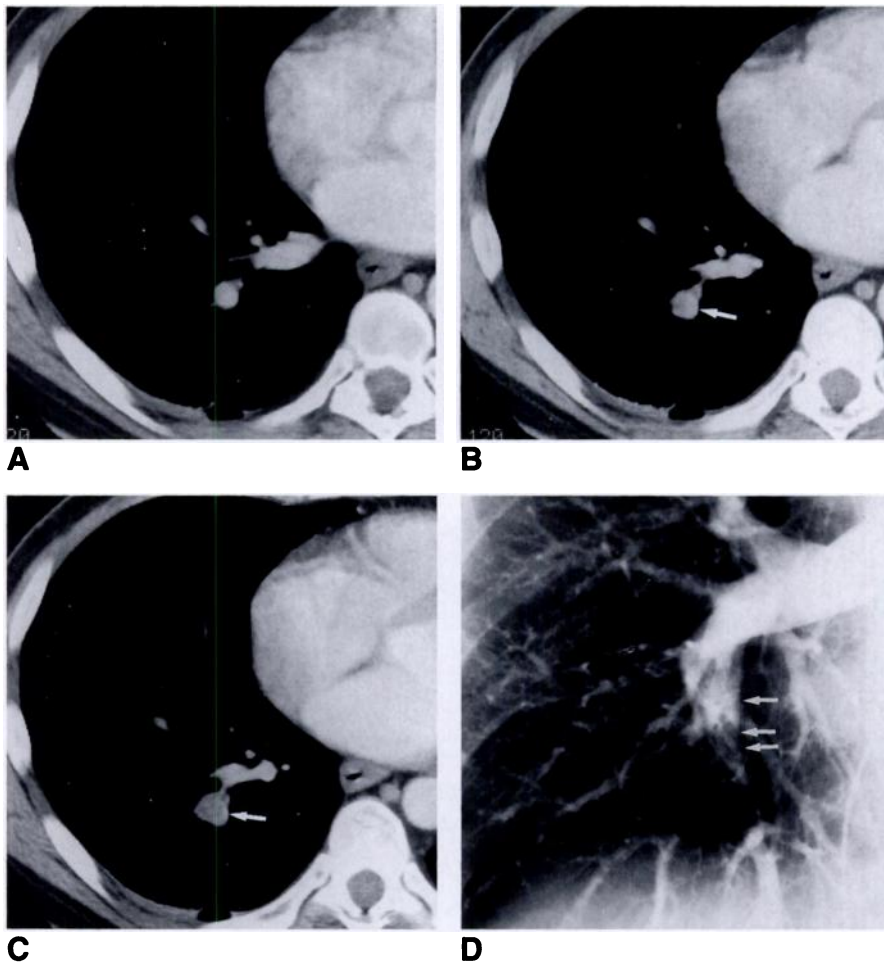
True-positive CT scan, subsegmental level. 72-year-old man with hypoxia and increased cardiac second sound. Clinical suspicion was moderate, and scintigraphic suspicion was low.
